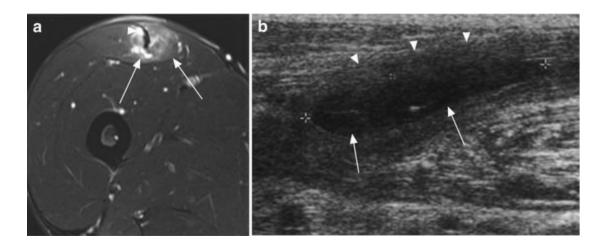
A 26-year-old football player with a Grade 2 muscle injury of the rectus femoris muscle. (a) Axial T2-weighted MRI shows diffuse hyperintensity surrounding the central tendon (arrows). In addition, there are small patches of fluid-equivalent signal intensity (arrowhead) defining this lesion as a grade 2 muscle strain. (b) Longitudinal ultrasound image shows liquid-equivalent hematoma (hypoechogenic area depicted by arrows). In addition, there are more diffuse edematous changes seen surrounding the hematoma (arrowheads)
